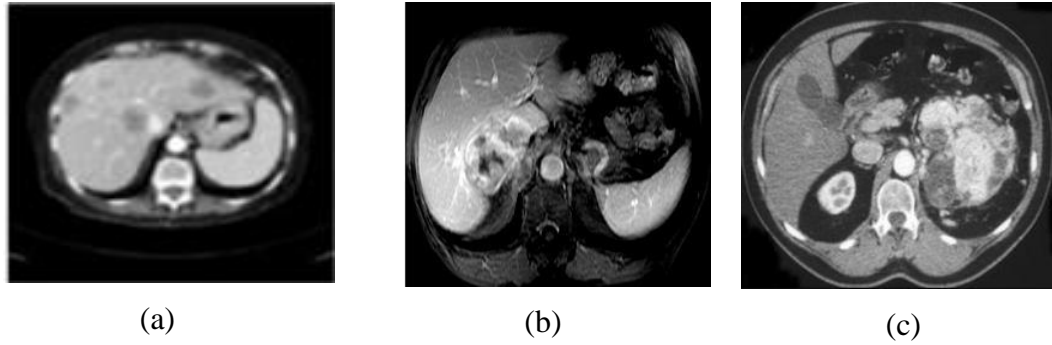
(a) Stomach CT medical image, (b) Adrenal CT medical image, (c) Kidney CT medical image [7]
